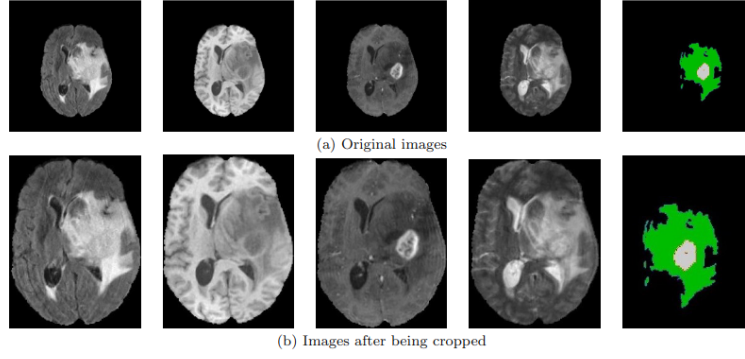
Cropped image from the Data. The columns from left to right are FLAIR sequences, T1 sequences, T1-CE sequences, T2 sequences and their corresponding masks
